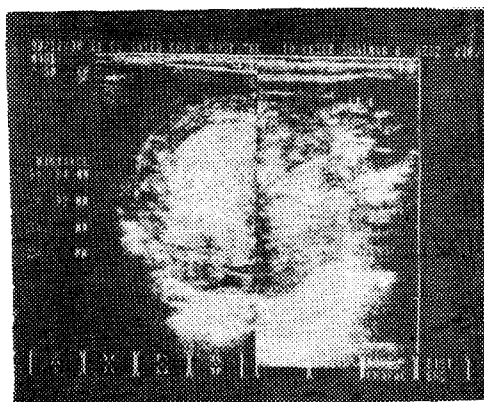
a) Nephrosonography of the left kidney showed : echogenic mass arising from its lower pole with echolucent areas and ipsilateral hydronephrosis.
